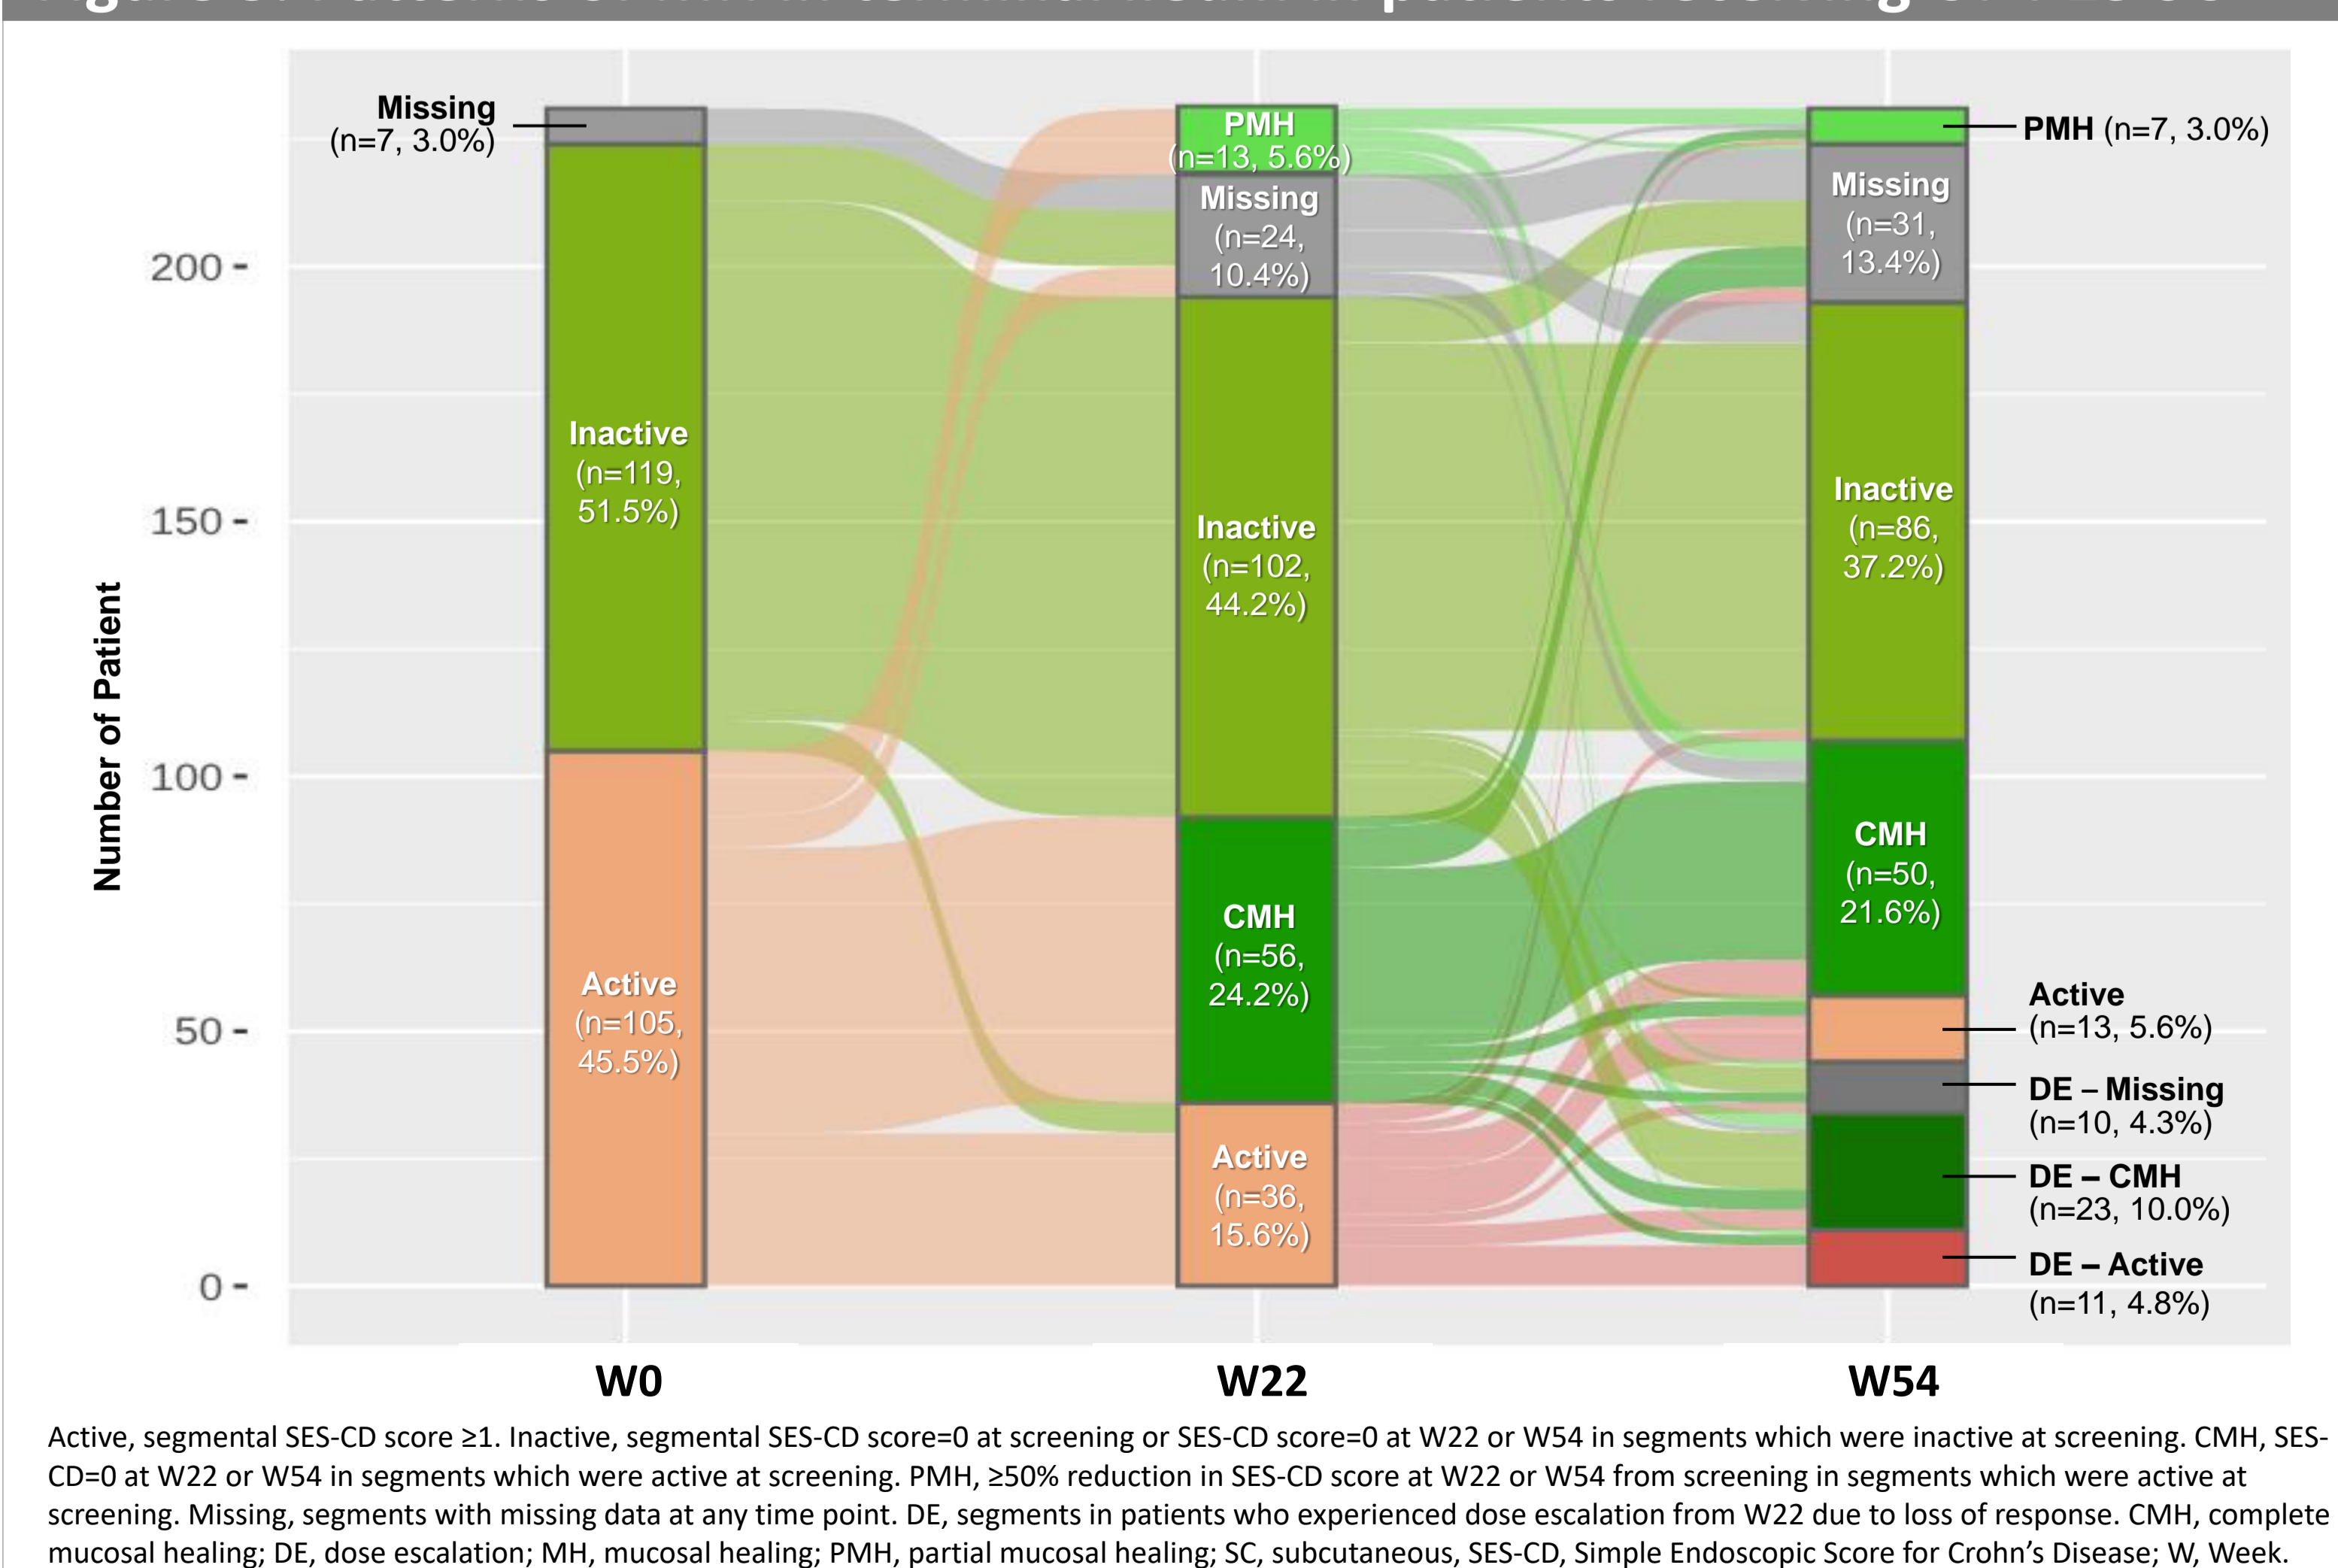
Patterns of MH in terminal ileum in patients receiving CT-P13 SC
